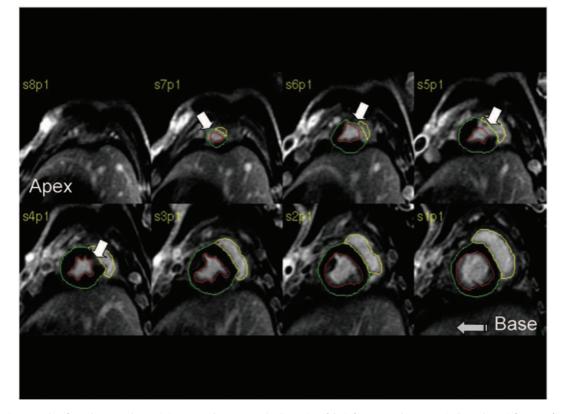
Representative examples of LV Gd-DE MRI short-axis images used to measure the dimension of the infarct scar. White arrows indicate the LV infarct scar from left ventricular base to apex.
